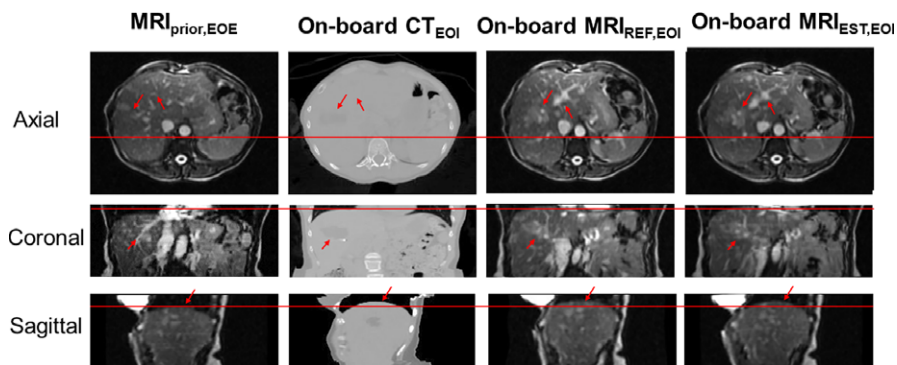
The columns from left to right show: Prior MRI ( $MRI_{prior}$ ) at EOE phase, on-board CT at EOI phase, reference on-board MRI at EOI phase and estimated on-board MRI at EOI phase for the patient study. The rows show the axial, coronal, and sagittal views, respectively. The horizontal line and arrows indicate areas for comparison. [Color figure can be viewed at wileyonlinelibrary.com]
